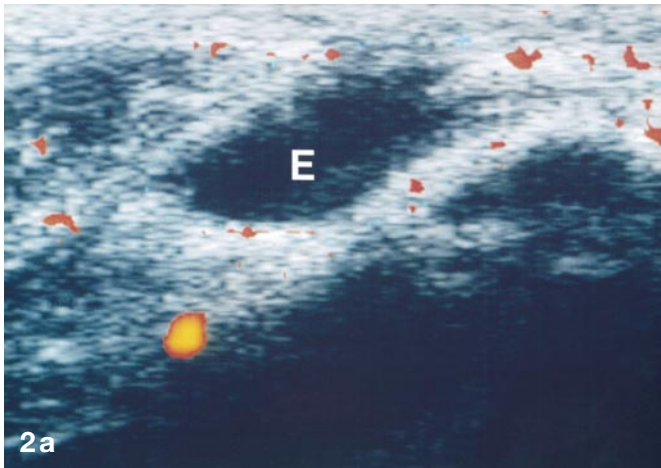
a Sagittal view of the suprapatellar area of a rabbit knee immediately after the injection of 1 cc of saline. Minimal power Doppler signal is present (*E* effusion). b Sagittal view of the suprapatellar area of a rabbit knee 4 days after the injection with *S. aureus*. Diffuse increased power Doppler signal is present within soft tissues peripheral to the effusion (*E*) within the suprapatellar pouch
